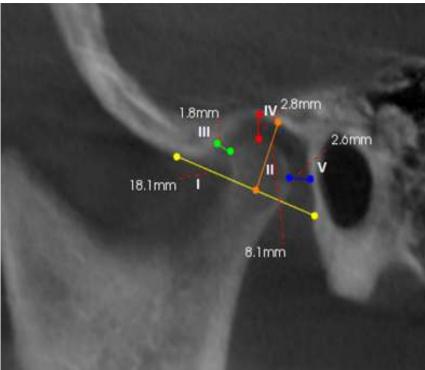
(a):- CBCT Variables and their measurements.
